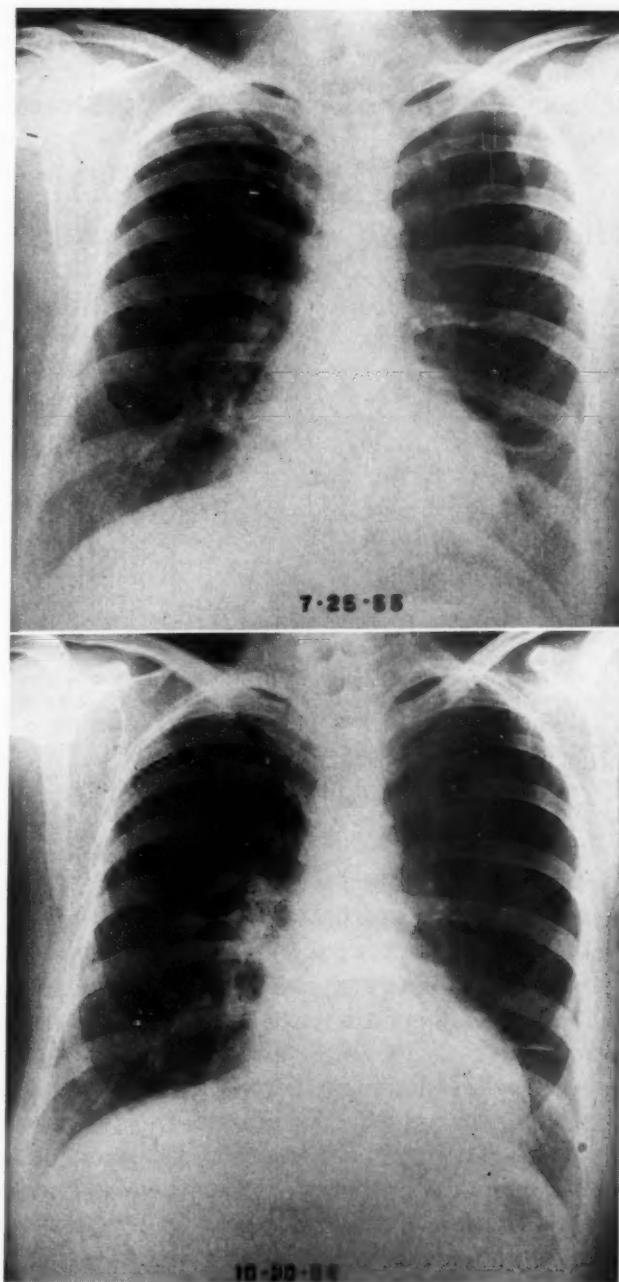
Frontal plane chest roentgenograms for comparison of heart size in Case 2.
